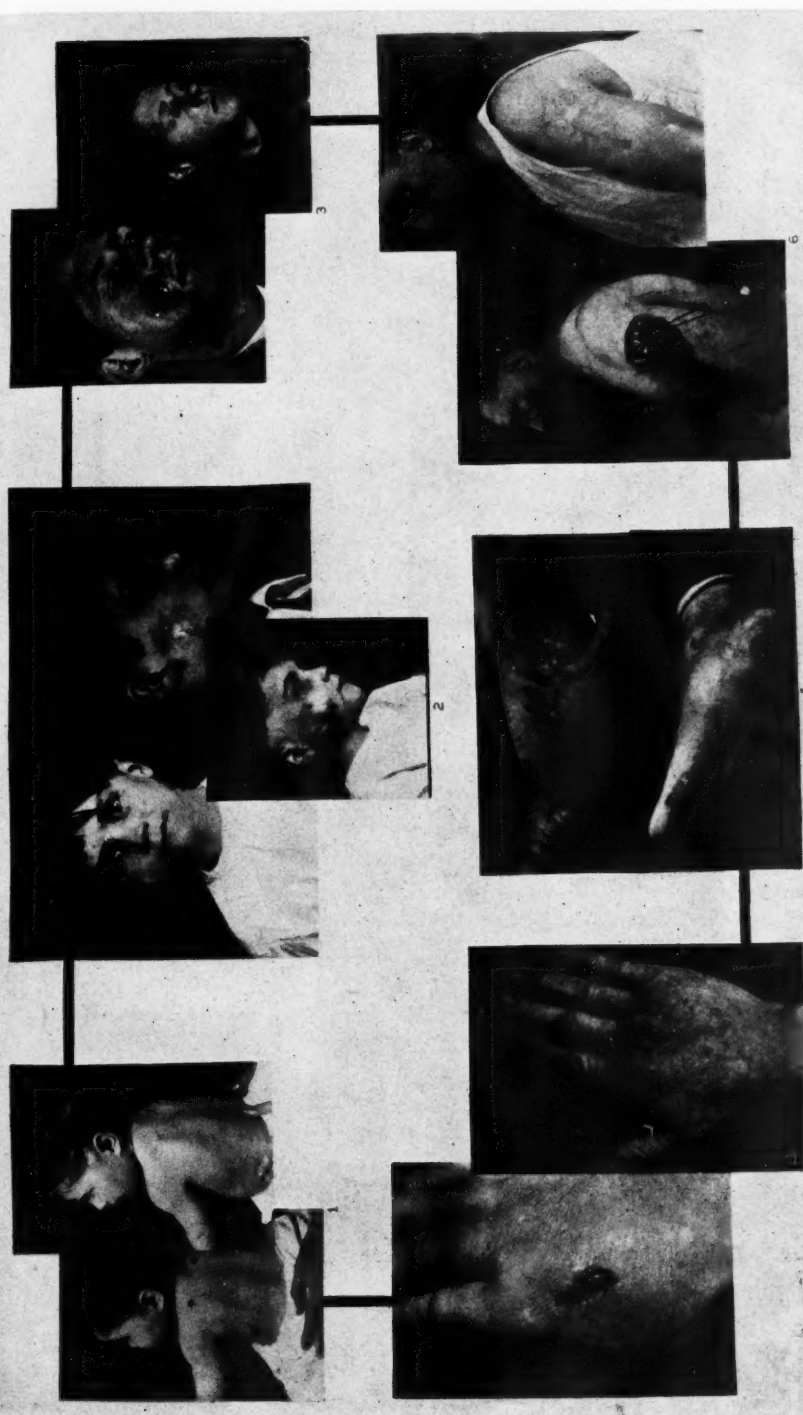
(1) Multiple hemangioma before and after treatment with radium surface applicator. (2) Hemangioma of the face before and after treatment with radium needle puncture. (3) Lupus of the face before and after treatment by endotherapy and X-rays. (4) Epithelioma of the hand before and after treatment with surface radium mold. (5) Melanosarcoma of the foot before and after treatment with X-rays, surgery, and radium. (6) Sarcoma of the arm before and after treatment with X-rays, surgery, and radium.
